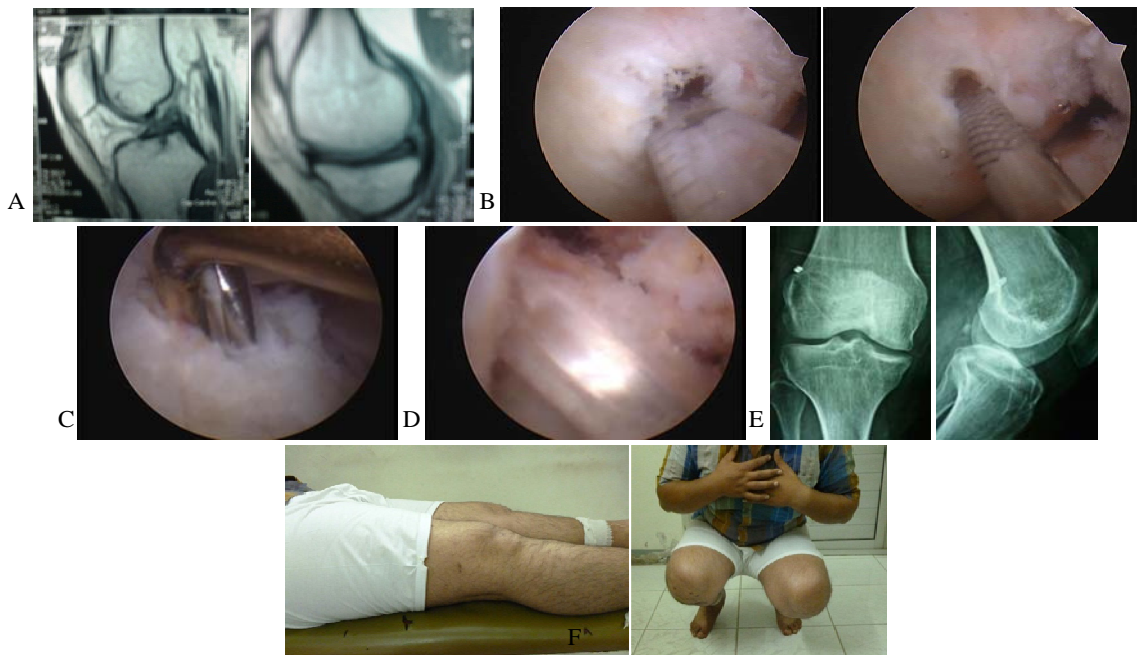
Male patient 21 years old presented with ACL tear. A- M.R.I showing abnormal ACL signal. B- femoral tunnel drilling. C- tibial tunnel drilling D- the final graft position E- postoperative x-ray showing the tunnels position F- Photos show final clinical outcome
